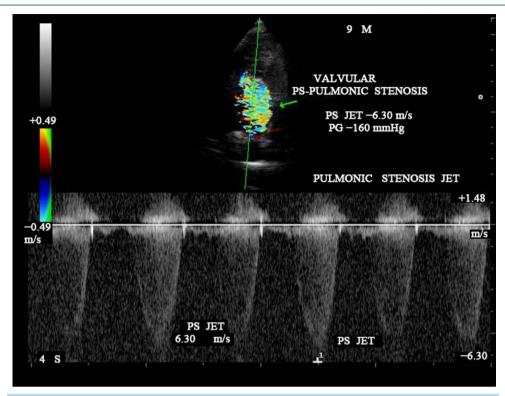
CW (continuous wave) doppler showing the velocity (6.30 m/s) and gradient (160 mmHg) of PS (pulmonary valve stenosis) jet.
